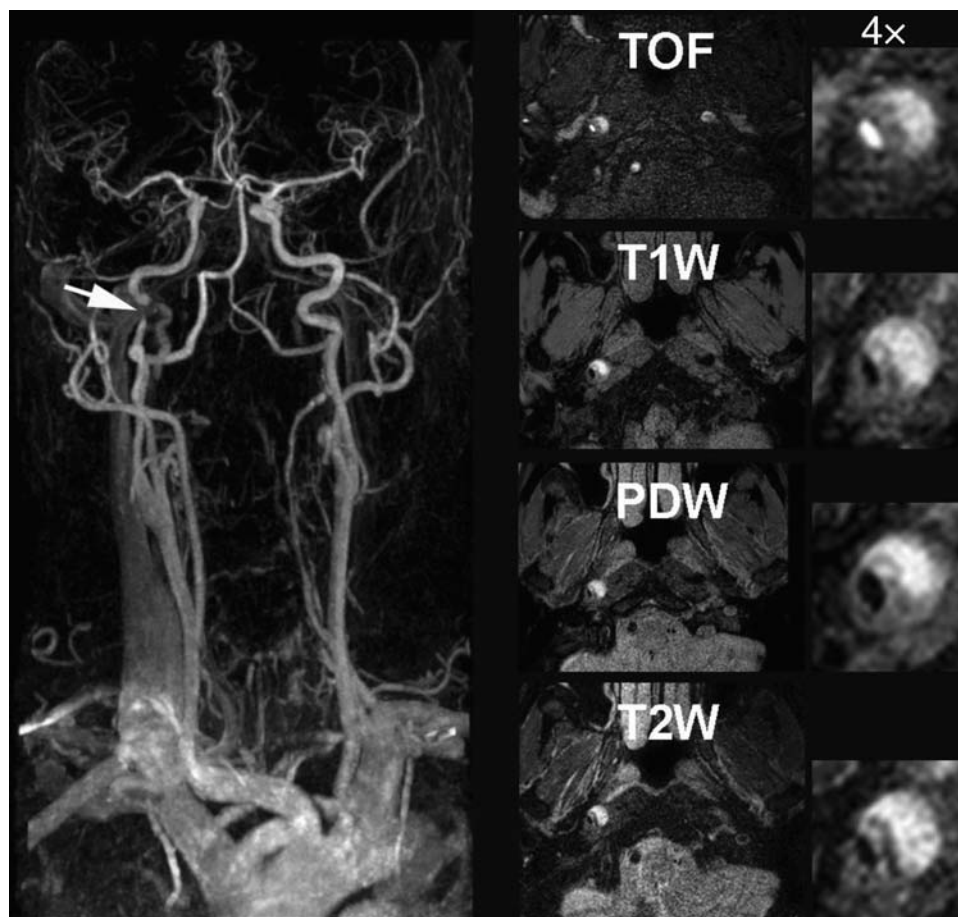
Magnetic resonance angiography demonstrating a subtotal stenosis of the right internal carotid artery (arrow) in a patient with acute stroke. High-resolution multicontrast imaging demonstrates a disrupted plaque with intraplaque haemorrhage as a cause of the subtotal obstruction (middle panels). Details of the cross-sectional multicontrast magnetic resonance images (four-fold enlargement) are provided in the right panels (published with the permission of Prof. Dr A. Gallino and Dr R. Wytenbach, Bellinzona, Switzerland).
